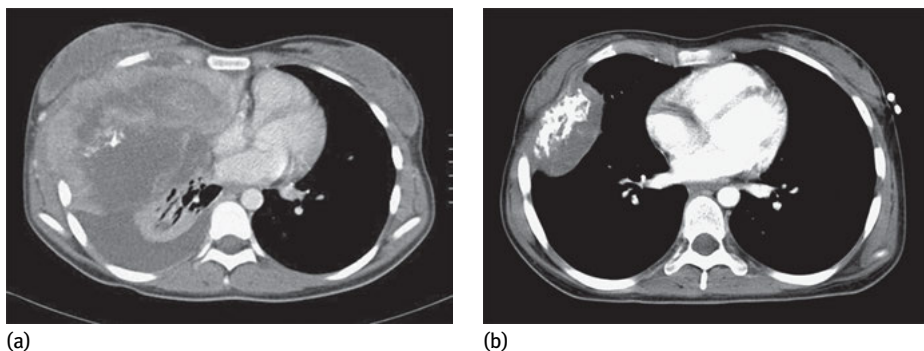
Initial CT scan of a Ewing sarcoma of the right chest wall (a) and same patient after neoadjuvant chemotherapy (b).
